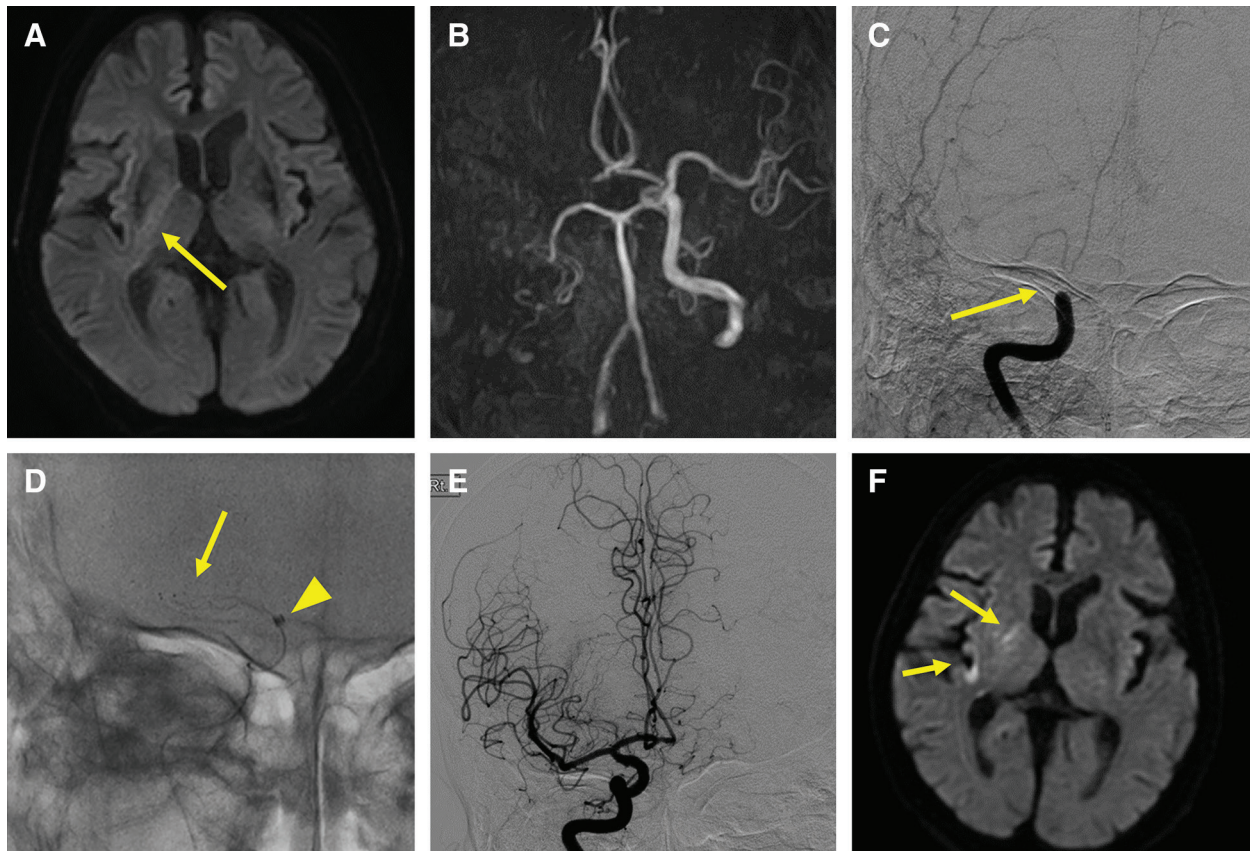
Case 1. (A) Preoperative MRI-DWI. A light high-signal-intensity area was detected in the posterior limb of the right internal capsule (arrow). (B) Preoperative MRA. The right ICA was not visualized. (C) Frontal view of cerebral angiography. Occlusion at the end of the right ICA was observed (arrow). (D) Frontal view on fluoroscopy. A Trevo XP 6 × 25 mm was deployed in the M1 segment of the right middle cerebral artery (arrow) and a Penumbra ACE 60 was guided
